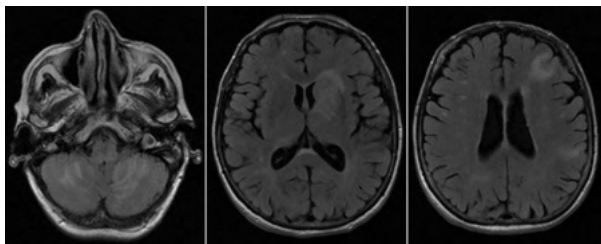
MRI FLAIR sequence showing hyperintensity foci in the cerebellum, left basal ganglia and subcortical zone of the left frontal and parietal lobes.
